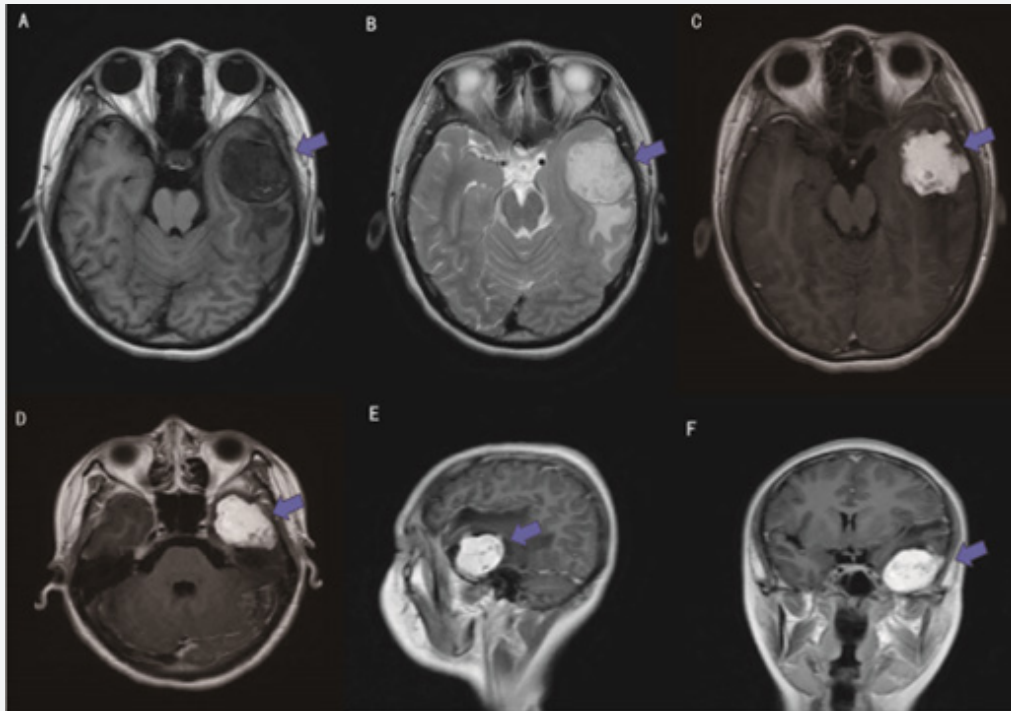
A The tumor is low signal in T1-weighted image with clear boundary. The tumor is surrounded by a large edematous band of high signal in the T2-weighted image. C-F enhancement scan, the tumor is significantly strengthened.
